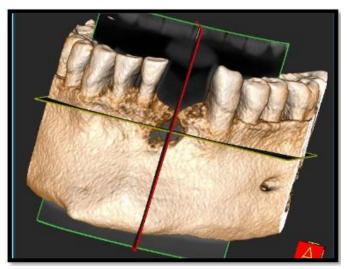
3 D view of CBCT representing the bony defect/perforation of buccal bone
